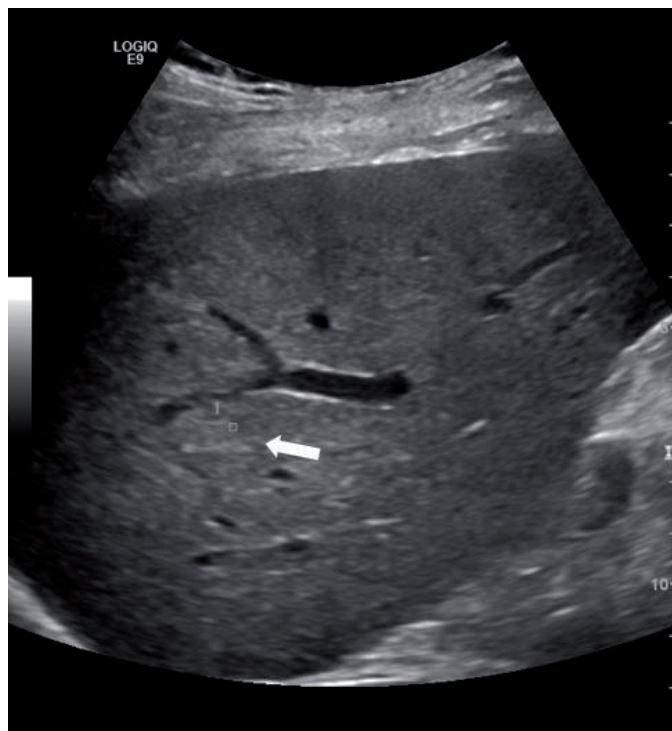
The mass in segment VII (arrow) is barely discernible as a well-circumscribed, heterogeneous mass using conventional ultrasound.
